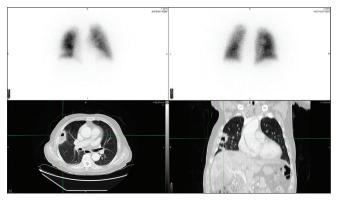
Images of a false-positive Q-only imaging study with planar anterior and posterior images demonstrating a wedge-shaped defect in the right middle lobe which was reported as high probability study. A diagnostic CT scan performed 20 days later demonstrated a cavitary lesion which yielded malignant cells on biopsy. CT = Computed tomography
